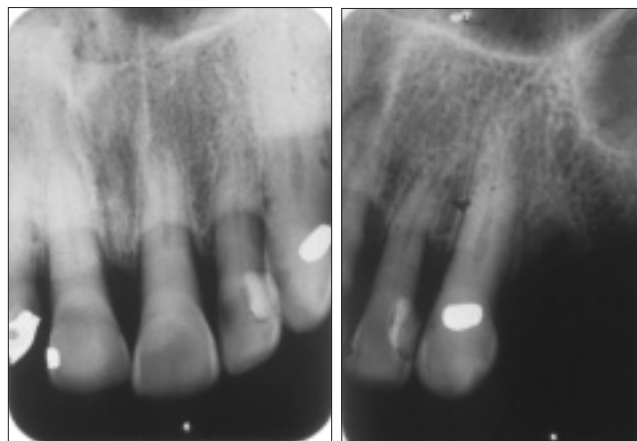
Periodontal disease. The diagnosis of periodontal disease from this panoramic radiograph is clear, but how useful are panoramic views in monitoring disease progression over time? Does the reduced radiographic exposure offered by such views affect their diagnostic effectiveness, relative to periapical views (Figs. 3b and 3c)? Diagnostic assessment of such radiographs suggests that agreement between periapical and panoramic views may be as low as 55%.²⁶
